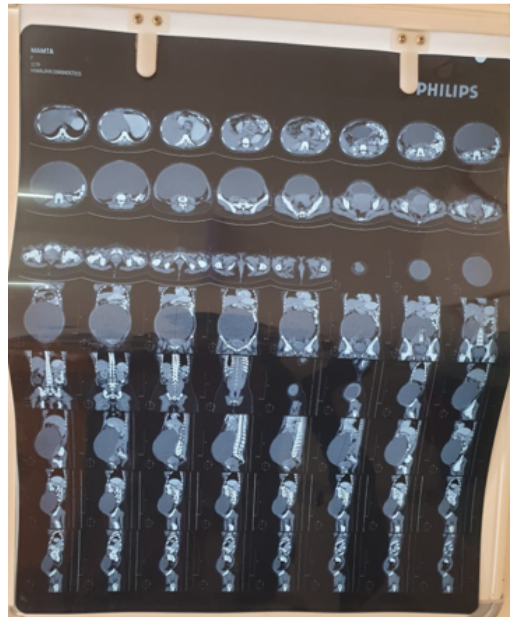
CT scan of abdomen and pelvis showing 25×16×27cms non-enhancing cystic lesion anterior to the uterus and superior to the bladder.
